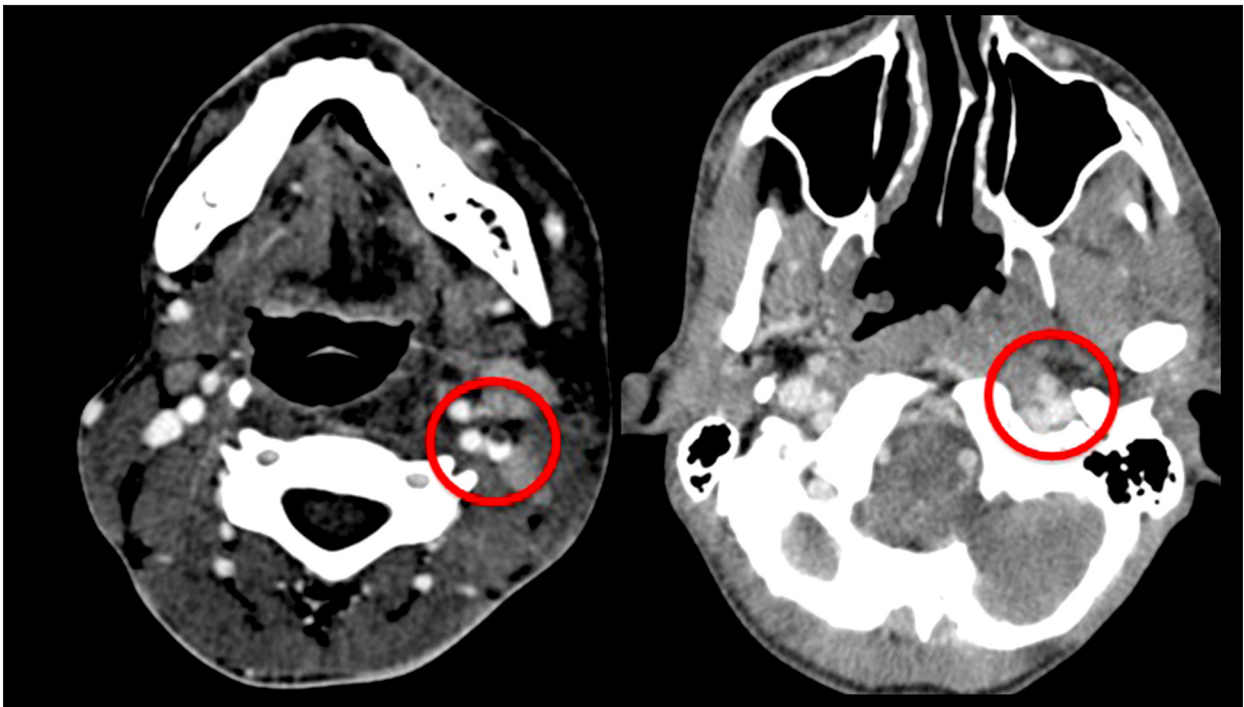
CT of the head and neck showing thrombosis of the left pterygoid venous plexus leading to internal jugular vein filling defect.
